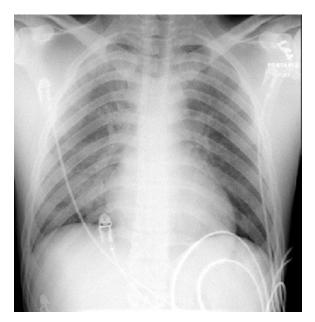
Posterior–anterior chest radiograph of a postresuscitation drowning patient. Reproduced with permission from THE UNIVERSITY OF VIRGINIA.
